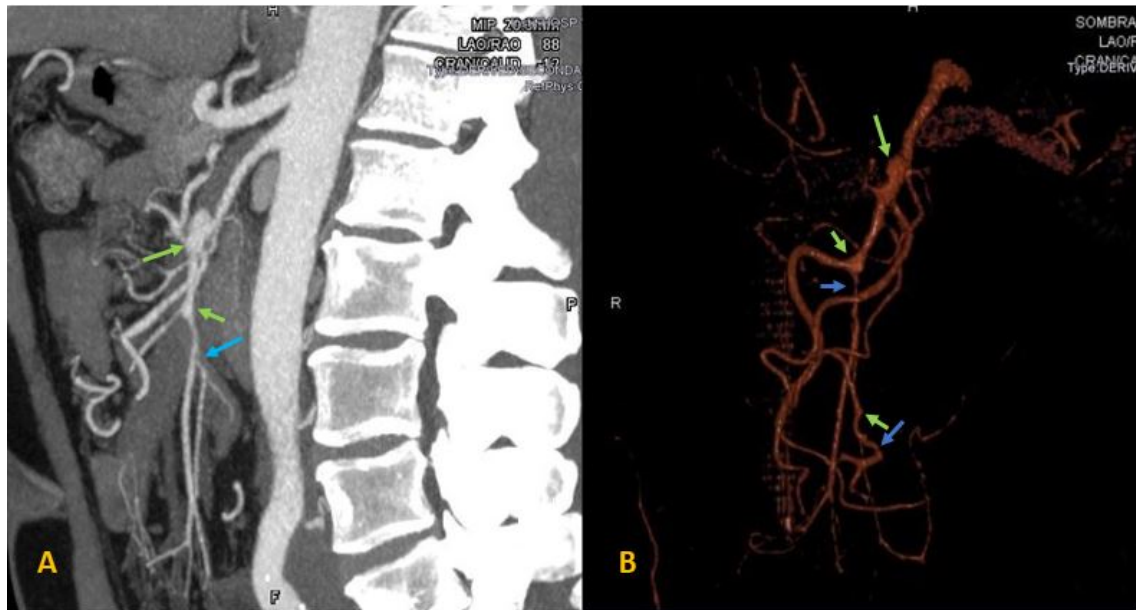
Abdominopelvic CT/angio-CT reconstructions. Green arrows show the aneurysmal vascular dilatations and blue arrows show the obliterated vascular segments in the superior mesenteric artery and distal branches. The findings were consistent with segmental arterial mediolysis.
